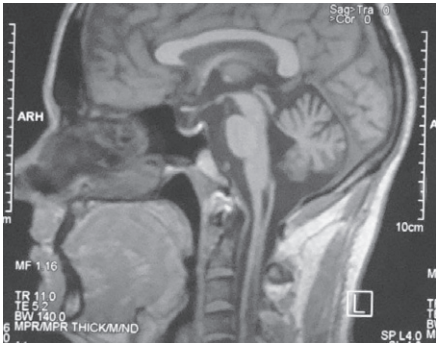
MRI (T1-weighted sagittal image) showing reduction in the syrinx after syringosubarachnoid shunt
